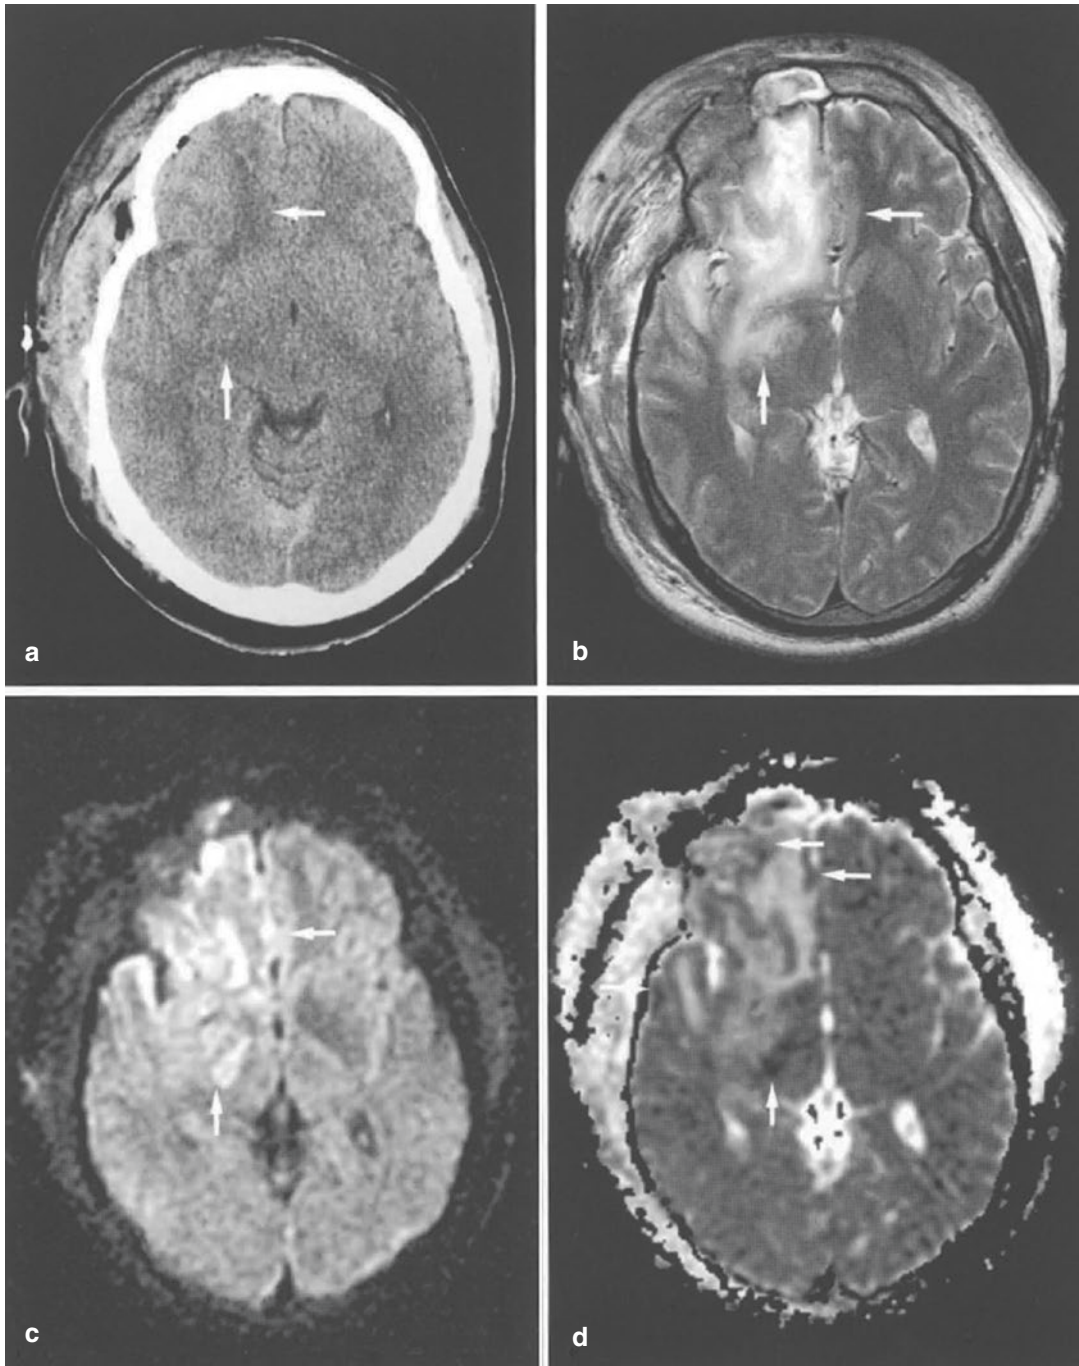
(a–d) Brain contusion in the frontal lobe in a 37-year-old man after a motor vehicle accident. (a) On CT obtained after evacuation of epidural hematoma, it is difficult to delineate the extent of contusion in the right frontal lobe (*arrows*). (b) T2-weighted image delineates the extent of the edematous brain contusion (*arrows*). (c) DW
